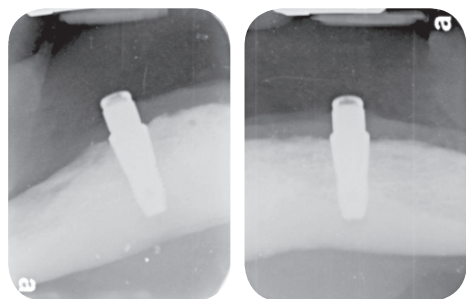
Periapical X-ray film of implants with Locator® abutments.
